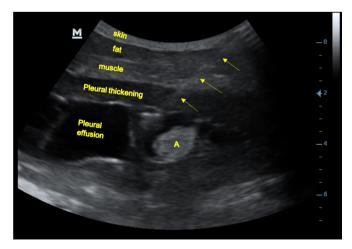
Ultrasound anatomy during cutting needle biopsy. Yellow arrows=biopsy needle track; A=meshwork of closely interlaced septations.
